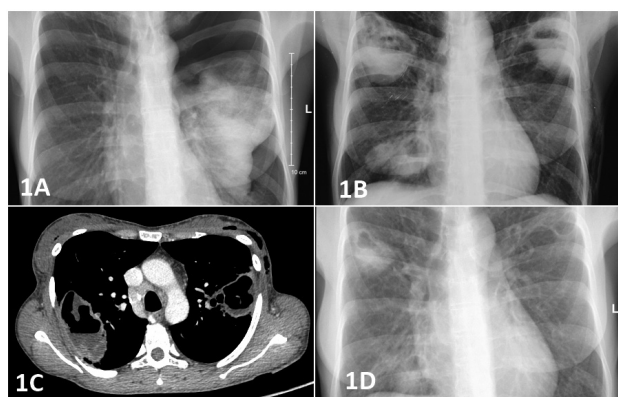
1A) Left sided pneumothorax with a contralateral cavitation; 1B) Bilateral cavity lesions; 1C) Computed tomography scan showed bilateral necrotising pulmonary lesions; 1D) Radiographic regression after two weeks of voriconazole treatment.
